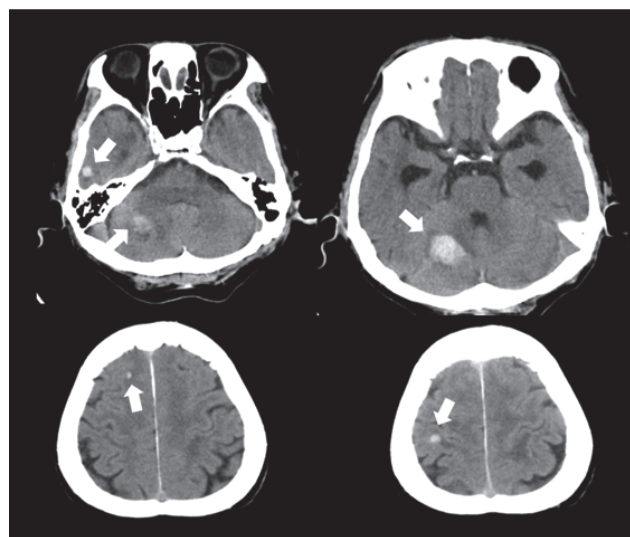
Computed tomography scan on admission revealed multiple intracerebral hemorrhage. White arrows indicate cerebral hemorrhage.
